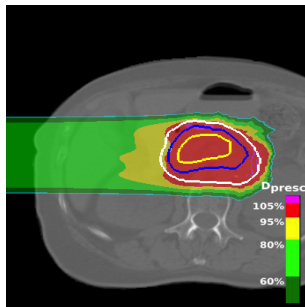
Forward calculated dose distribution in the CT₃ for all the patients of the dataset A with the lateral beam of the plan optimized to the geometric ITV_{5mm}.
